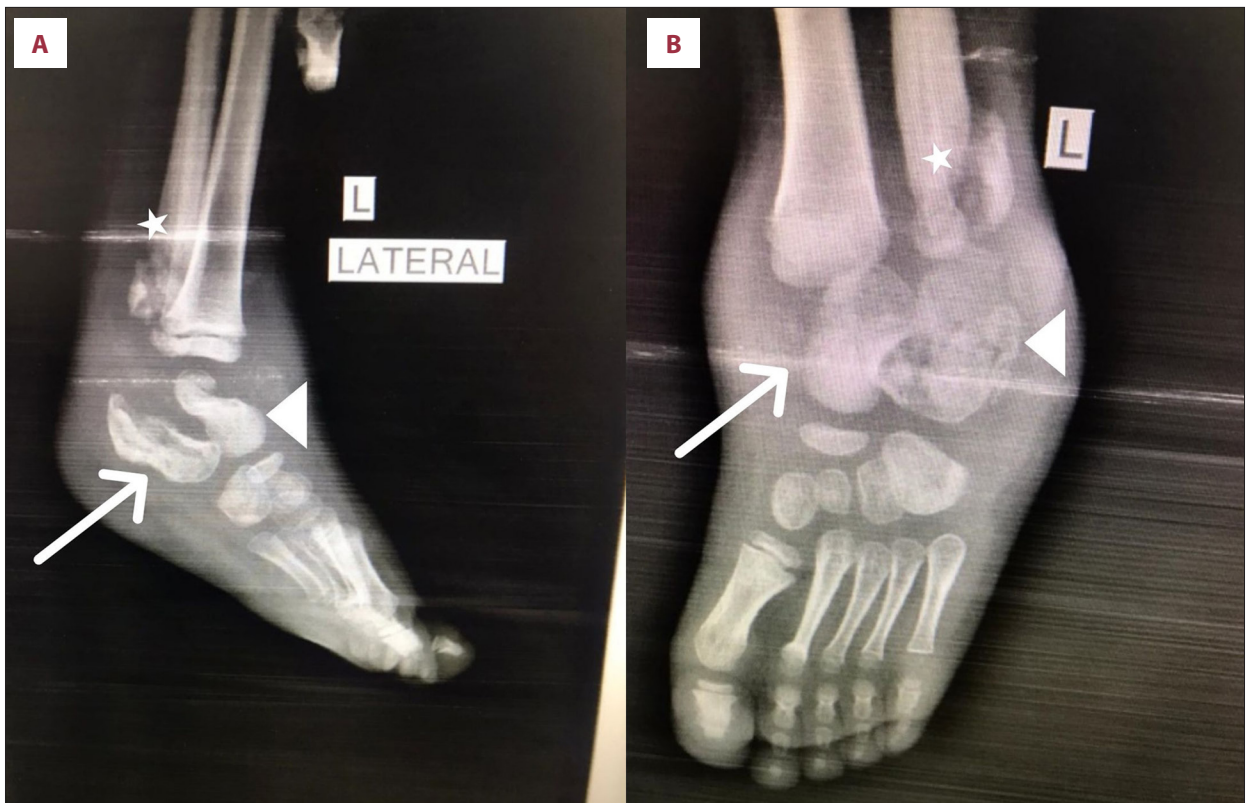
Left foot X-ray, diffuse osteomyelitis involving the talus (arrow), calcaneus (arrow head), and distal fibula (star). (A) Lateral view X-ray of the left foot. (B) Anterior-posterior view X-ray of the left foot.
